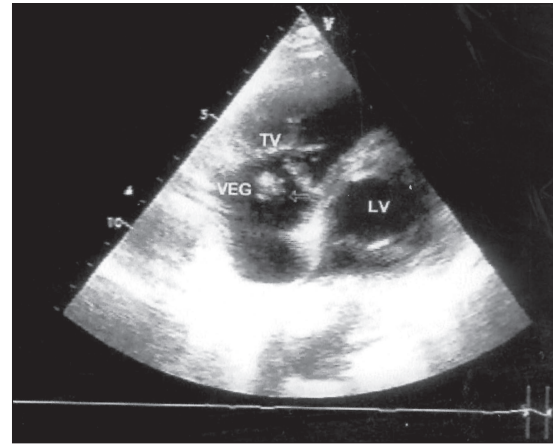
Transthoracic echocardiogram 4 chamber view showing vegetation (VEG) on tricuspid valve (TV). LV - Left valve.
